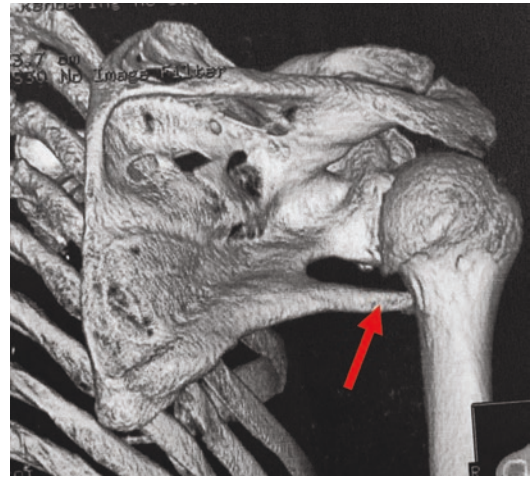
3-D CT scan of a right shoulder (posterior view). A large post-traumatic ossification (arrow) causes compression of the axillary nerve
